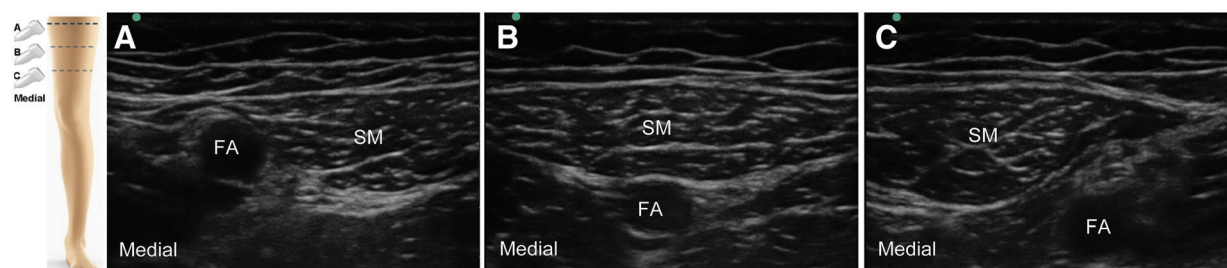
Relative ultrasound probe positions and sonographic configurations of the sartorius muscle and femoral artery examined in this study. These include the muscle in lateral (A), superimposed (B), and medial position (C) relative to the artery. FA, femoral artery; SM, sartorius muscle.
